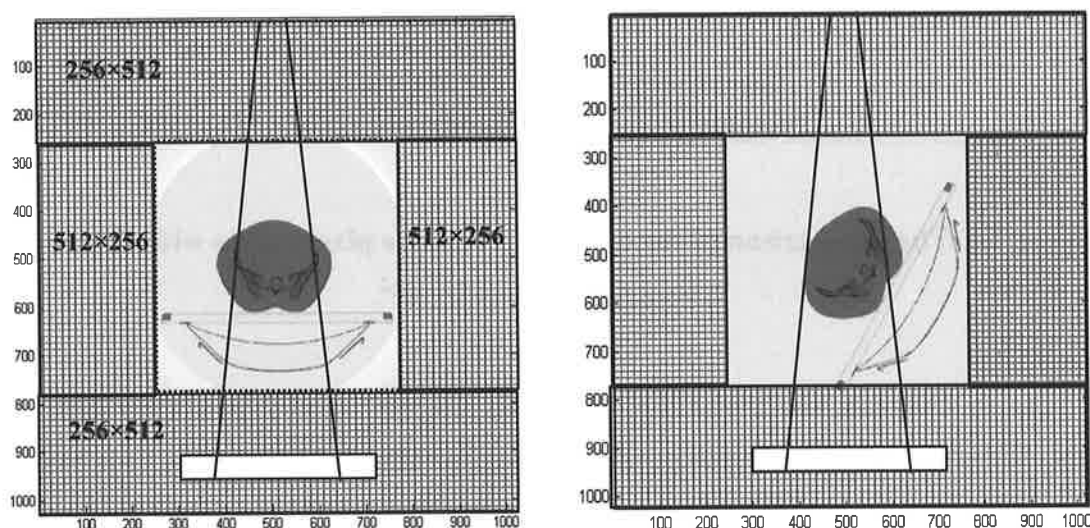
Typical extended CT image (a) in A-P direction and (b) at 60° gantry angle position. The position of modelled EPID is shown in both cases.
